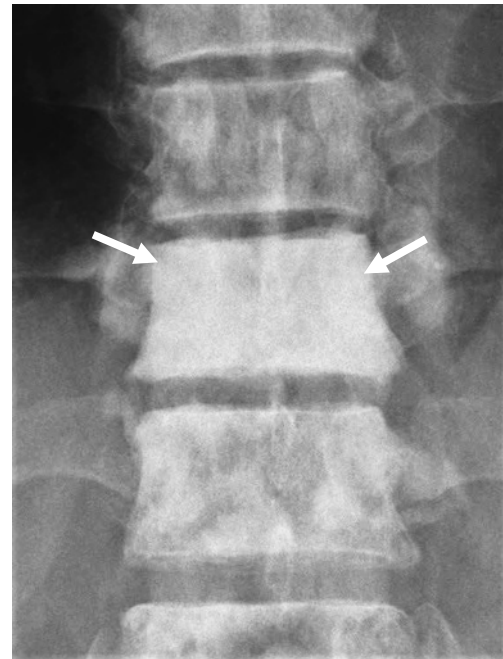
Radiograph showing a blastic pedicle sign in a 70-year-old man with metastasis of prostate cancer to the 10th thoracic vertebral. Bilateral pedicles on an anteroposterior radiograph are obscured by marked osteoblastic change in the vertebral body (arrow).
